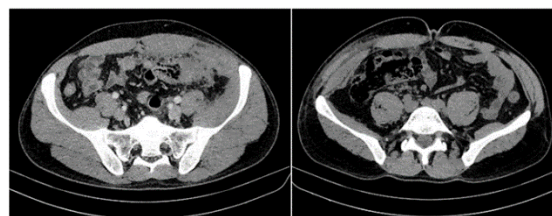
Preoperative computed tomography of the abdominal cavity and pelvic organs with contrast
